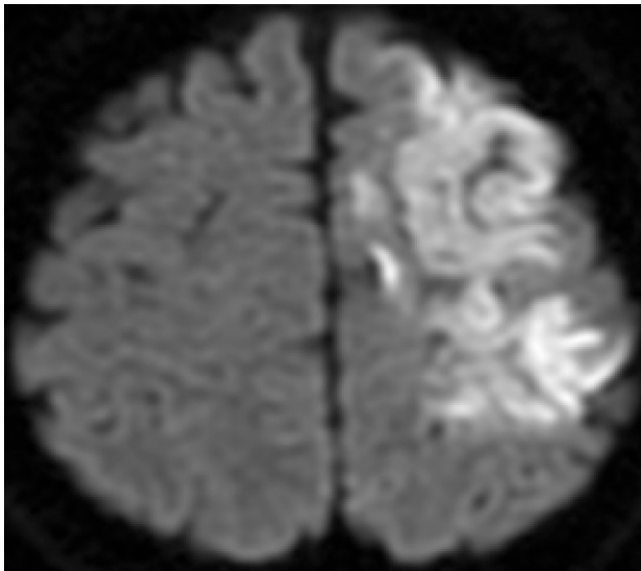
Diffusion-weighted magnetic resonance imaging revealed cerebral infarction in the left cerebral hemisphere.
